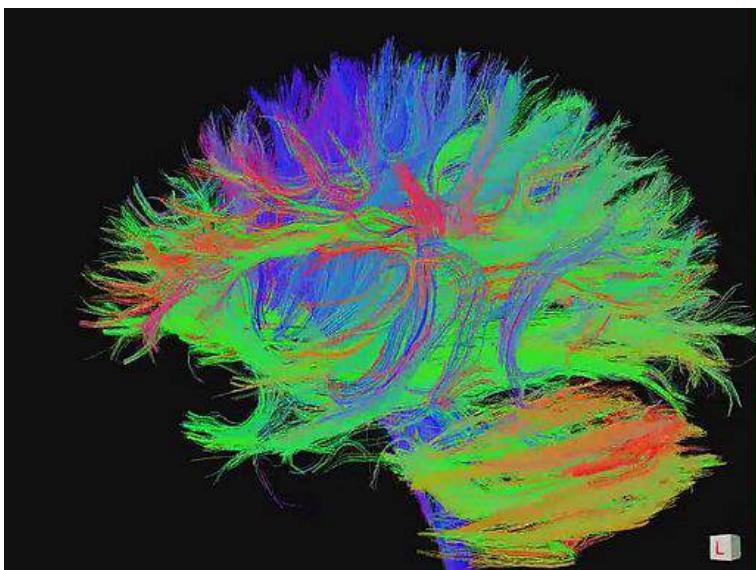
Why we are the way we are: networks of axonal nerve fibers in the brain as measured by Magnetic Resonance Imaging (MRI), specifically diffusion tensor imaging.
